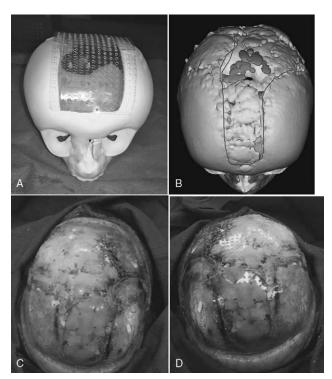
Large congenital cranial vault defect in a pediatric patient: A. CAD/ CAM model used intraoperatively to fashion resorbable mesh plates for bilaminar construct. B. Three-dimensional (3D) CT scan after 6 months of bone healing. C. Intraoperative apical view with endocranial plate and BMP-2 placed. D. Intraoperative apical view with ectocranial plate placed to finish the construct. CAD/CAM, computer-aided design and computer-aided manufacturing; CT, computed tomography.
